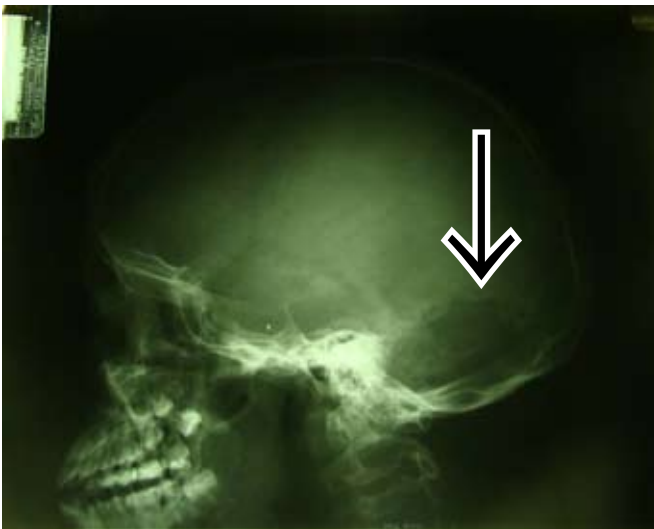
Lateral skull X-ray demonstrates defect in the lambdoid suture.
